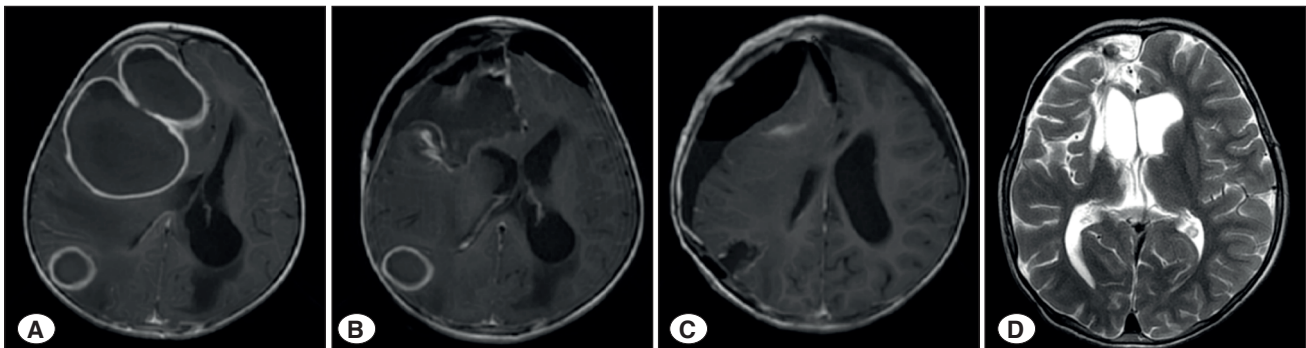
Representative case of a multiloculated intracerebral abscess in a 9-year-old boy. A) Contrast-enhanced T1-weighted (T1CE) magnetic resonance imaging (MRI) at presentation demonstrates multifocal intracerebral abscesses in the right frontal and right parietal lobes; the patient presented with a Glasgow Coma Scale (GCS) score of 14 and left-sided hemiparesis. B) Postoperative T1CE MRI following craniotomy and drainage of the right frontal abscess. C) Postoperative T1CE MRI obtained two days after the initial frontal surgery, following craniotomy and excision of the right parietal abscess. D) Follow-up T2-weighted MRI at 2 months after 8 weeks of parenteral antimicrobial therapy, showing complete radiological resolution; at this time point, the patient had fully recovered neurologically with a GCS score of 15 and no residual neurological deficit.
